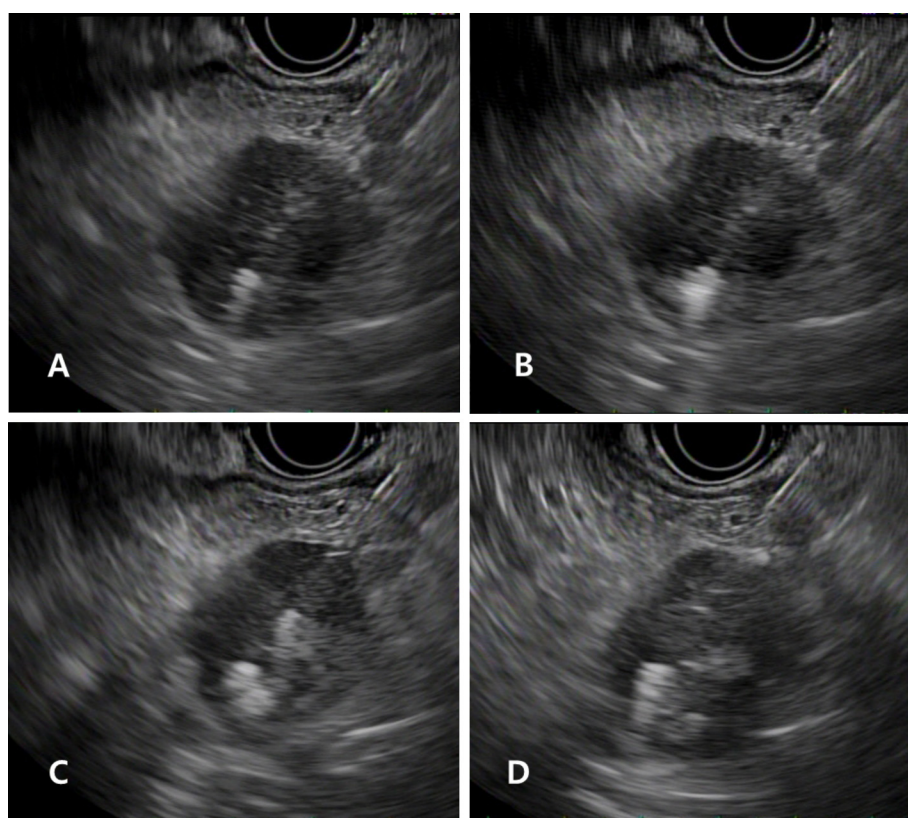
Image of EUS-RFA: a 19-gauge needle probe is inserted into the pancreatic tumor under EUS-guidance (A); ablation is usually started in the right distal part of the tumor on the EUS image at the far end inside the lesion (B); echogenic bubbles are identified around the needle after ablation (C); and after needle withdrawal and reinsertion into the mass, RFA is repeated on the left side of the previous ablation site (D). EUS-RFA: Endoscopic ultrasound-guided radiofrequency ablation.
